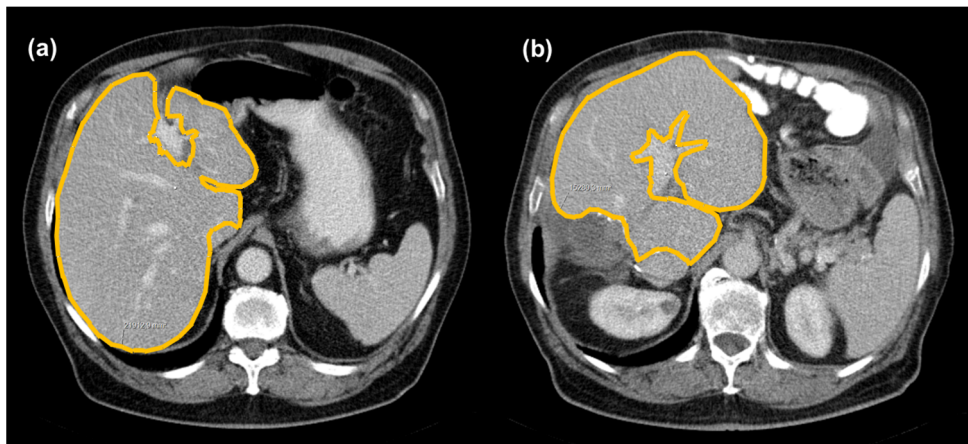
Picture of CT transversal plane images showing (a) preoperative liver area measurement and (b) post right hepatectomy liver area measurement about one year after surgery.
